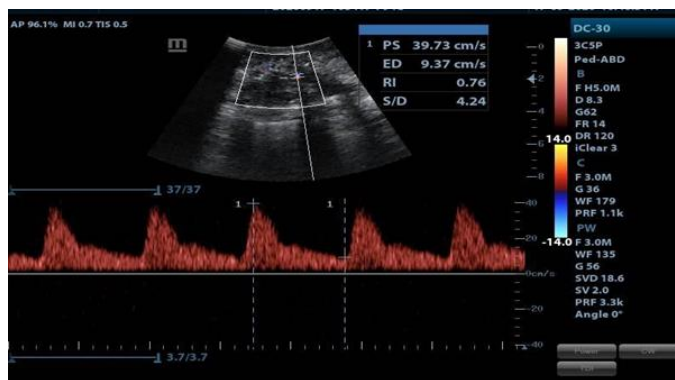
USG Color Doppler Of Breast Lesion
